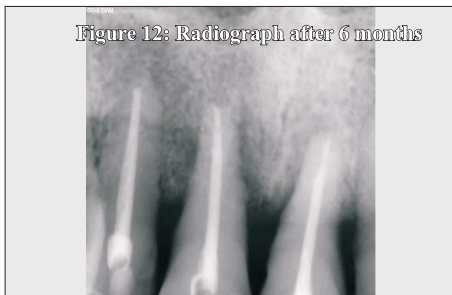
Radiograph after 6 months
